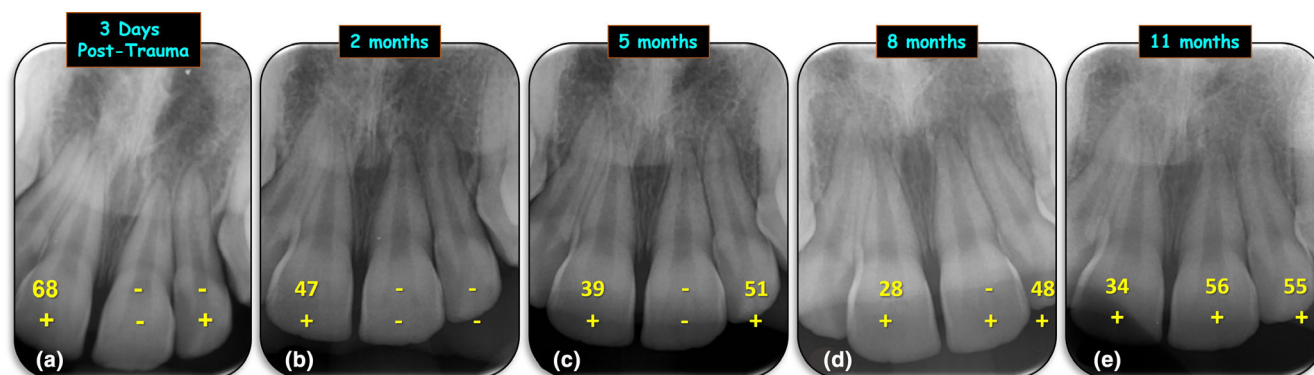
Example of the variable responses of teeth to pulp sensibility tests following a traumatic dental injury. The maxillary left and right central incisors and the right lateral incisor (teeth 11, 21, 22) had subluxations injuries. The teeth were reviewed regularly with clinical examinations, pulp sensibility tests and periapical radiographs. Radiographs and pulp test results are shown at: (a) 3 days after the injury; (b) Review after 2 months; (c) Review after 5 months; (d) Review after 8 months; (e) Review after 11 months. Footnote – KEY: yellow numerals represent the results of each tooth to electric pulp tests (scale 1–80); yellow ‘+’ sign indicates the tooth responded to a carbon dioxide dry ice test; yellow ‘-’ sign indicates no response to the carbon dioxide dry ice test.
